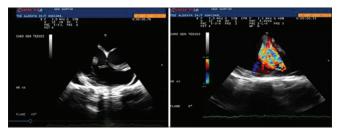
Transesophageal echocardiography images showing vegetation on anterior leaflet of tricuspid valve and severe tricuspid regurgitation.
